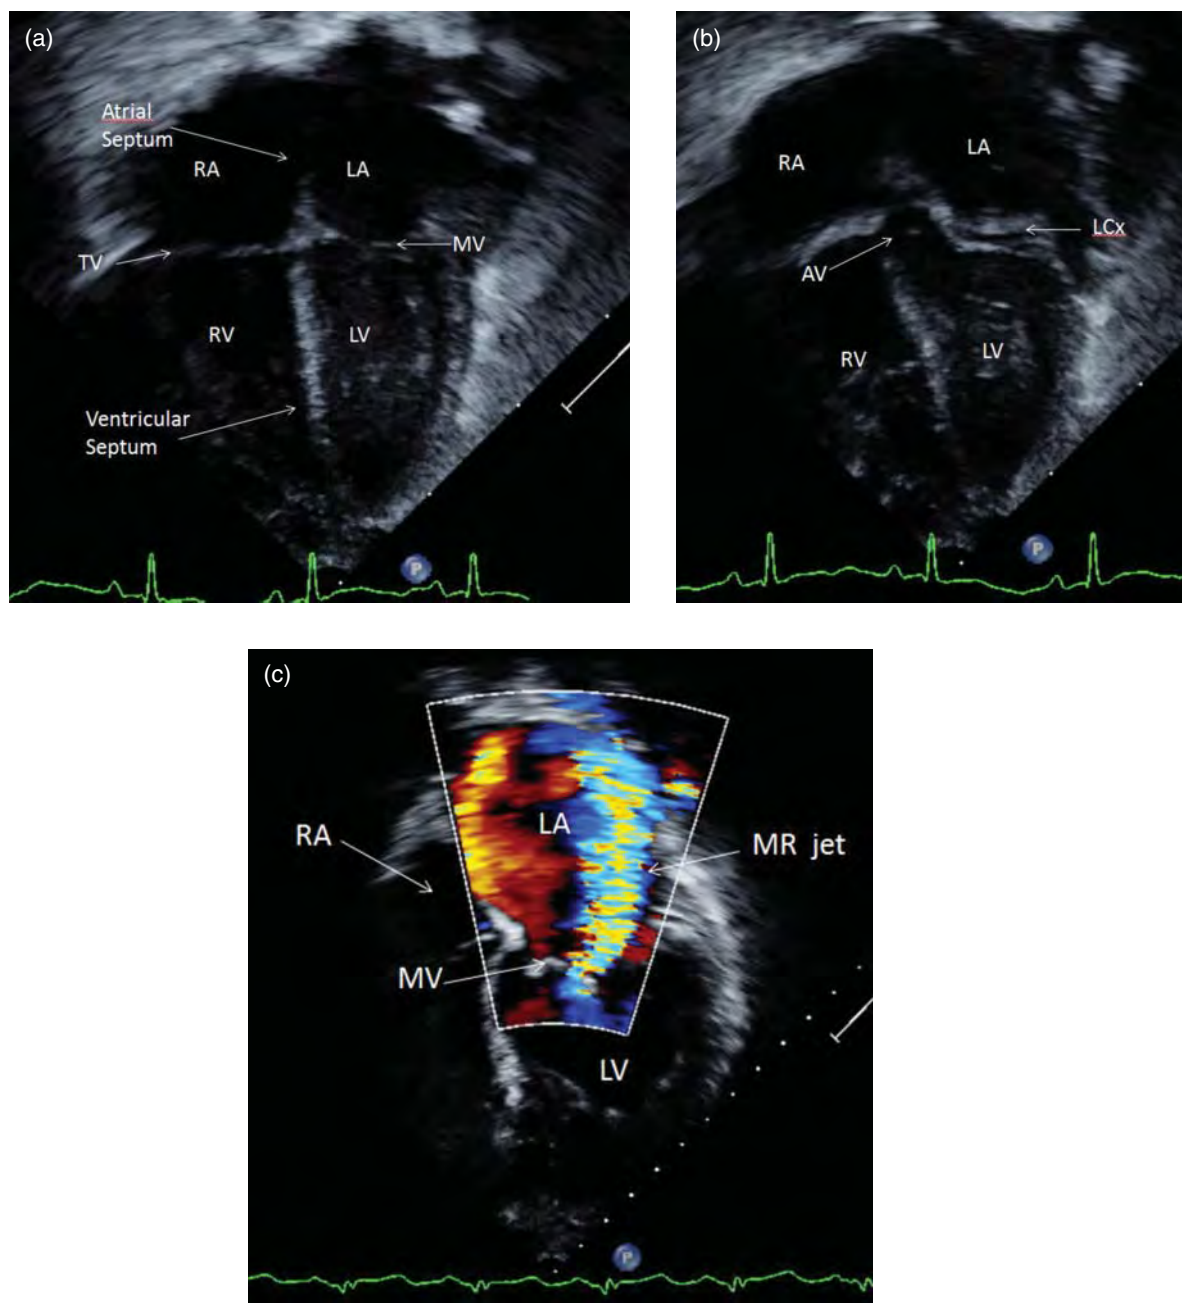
(a) Apical view demonstrating all four chambers: the left atrium (LA), right atrium (RA), left ventricle (LV), and right ventricle (RV). Both the mitral valve (MV) and tricuspid valve (TV) are well seen. (b) Tilting the probe anterior from the four-chamber view allows for visualization of left ventricular outflow tract and aortic valve (AV). The left circumflex coronary artery (LCx) is seen running adjacent to the mitral valve. (c) Apical four-chamber view with color flow placed over the mitral valve demonstrating a significant jet of mitral regurgitation (MR) directed back into the left atrium. The bright blue and yellow colors produced by the MR jet are related to the direction of flow and high velocity of the blood as it regurgitates back into left atrium (LA).
